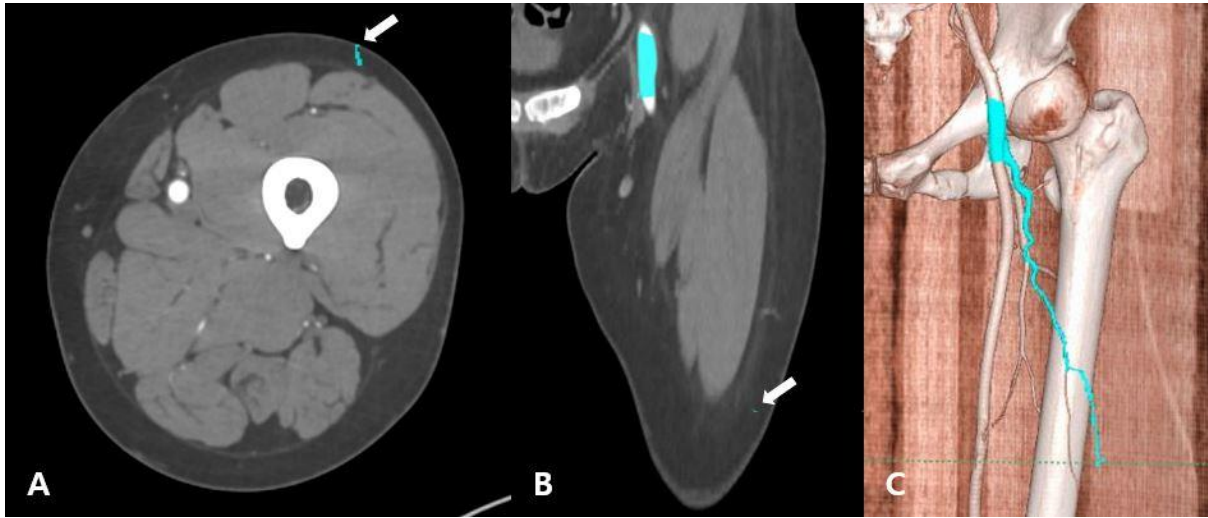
Axial (A), coronal (B), and 3D (C) views of computed tomography angiography. Manual mapping from the femoral artery near the hip joint to the lateral circumflex femoral artery perforator was performed continuously to the terminal point reaching the thigh skin.
